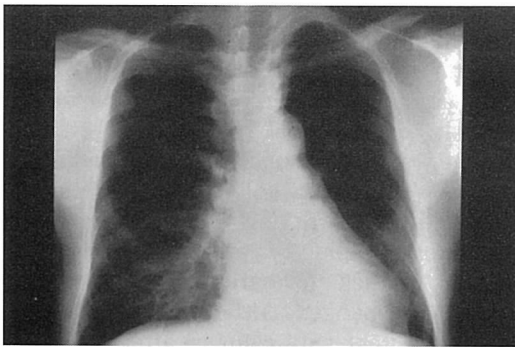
Initial chest radiography (Case 2) showing an infiltrate in the middle lobe. No abnormalities can be seen in any of the ribs.
